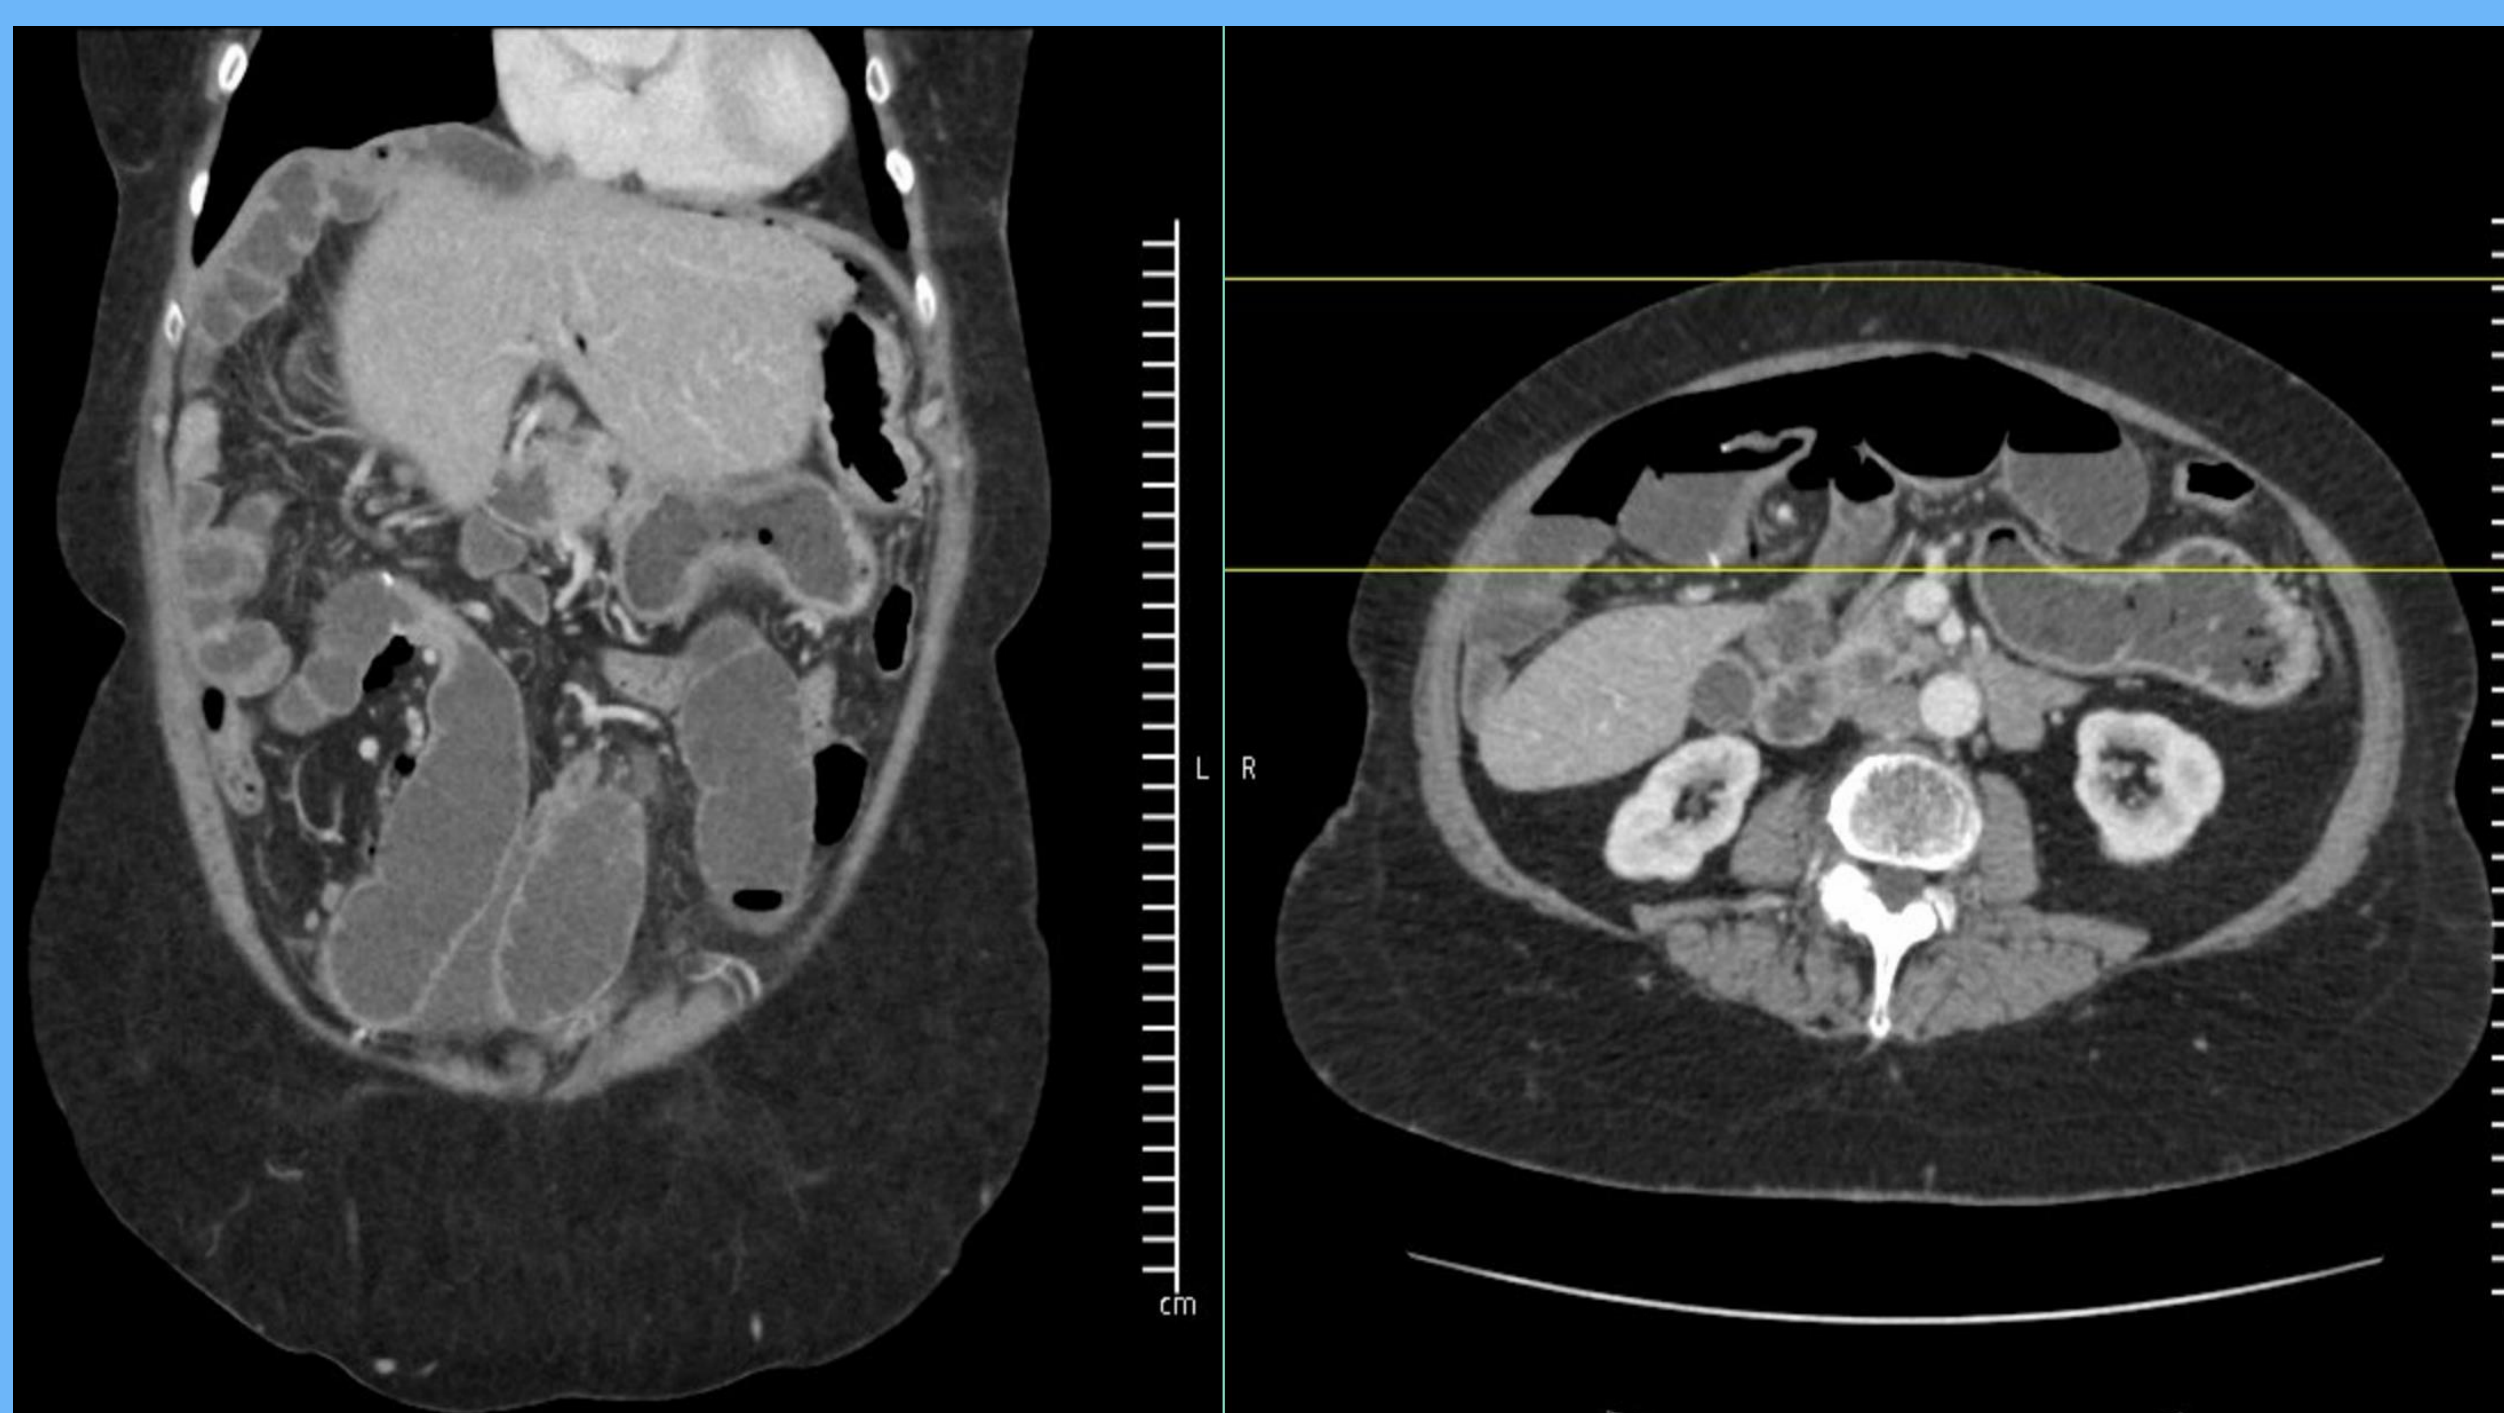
CT images demonstrating concerned area of volvulus with pneumoperitoneum
